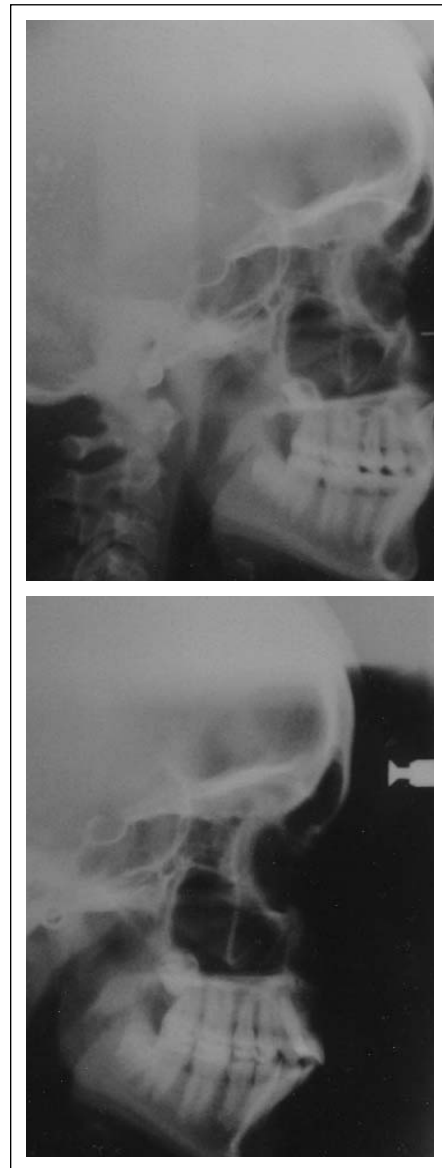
Pre and post treatment cephalograms of the patient 1. Note in the pretreatment radiograph that the incisor is almost at 120 degrees to the occlusal plane.
